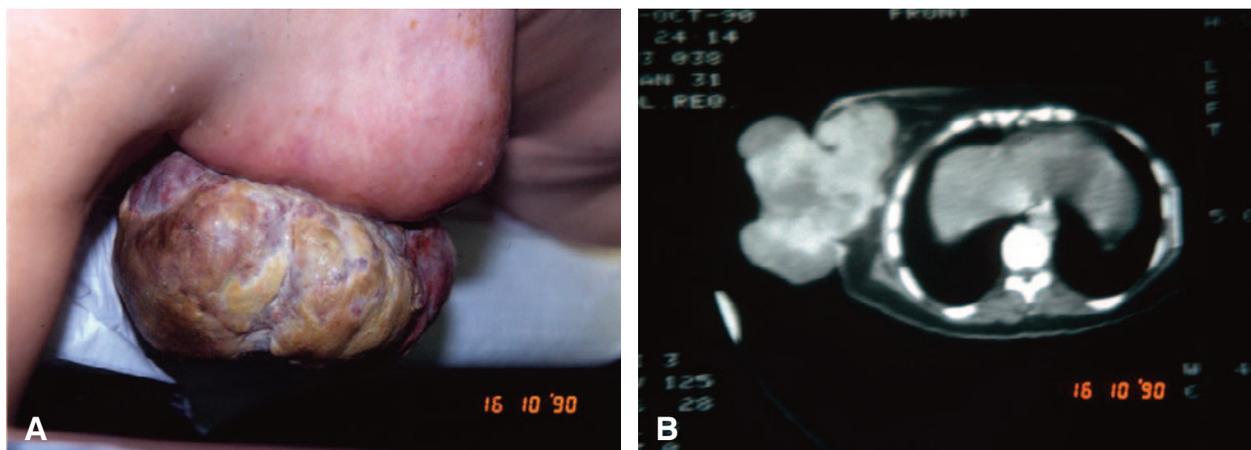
A. A large, fungating mass of the right breast in a 55-year old female patient (from the author's previous, West European experience). B. CT scan of the same patient. The mass is clearly identifiable.
